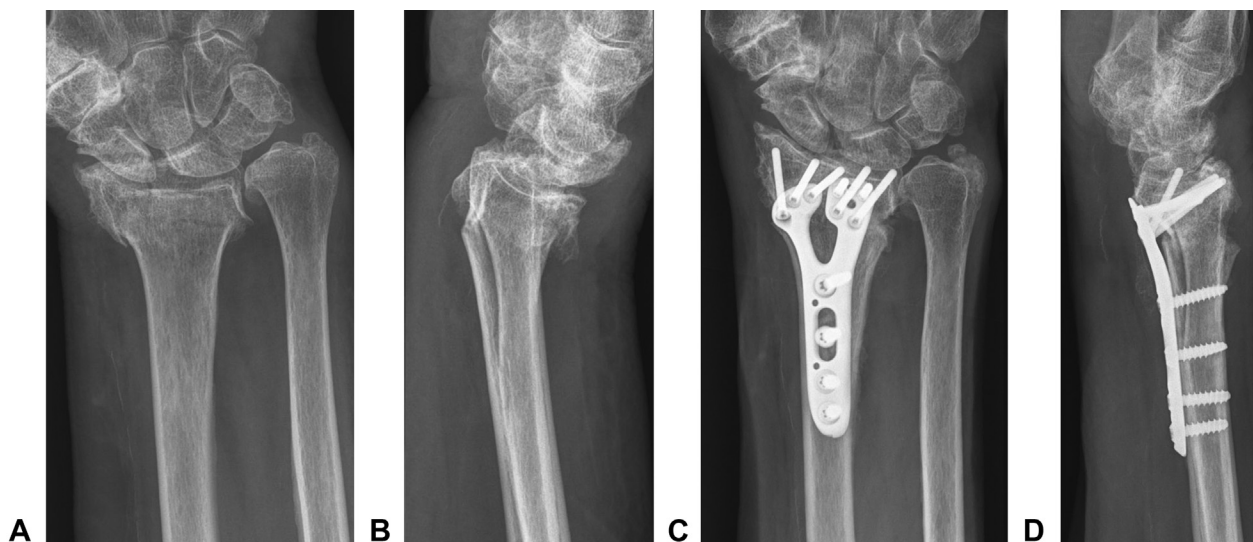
Preoperative A anteroposterior and B lateral radiographs showing acute DRF with evidence of malunion. Postoperative C anteroposterior and D lateral radiographs demonstrating correction of the acute and preexisting deformity using a VLP.
